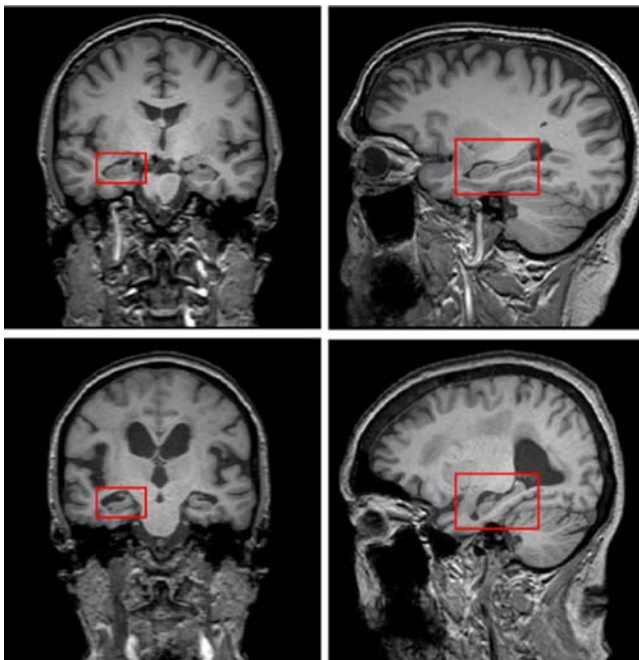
Examples of normal and accelerated hippocampal aging. These images show T1-weighted MRI, displaying both coronal orientation (left images) and sagittal orientation (right images). The hippocampus (boxed in all images) is larger in the top images. There is less cerebrospinal fluid (CSF), displayed as darker black regions, surrounding the hippocampus on the top images, supporting only slight atrophy. In contrast, in the bottom images, the hippocampus is more atrophic and there is more CSF surrounding the hippocampus. Notably, the bottom images also display enlarged ventricles.
